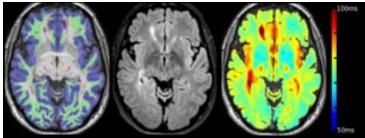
T1-weighted image showing segmentation of cortical gray matter (blue), juxtacortical white matter (green) and major white matter tracts (forceps minor, corticospinal tract, anterior thalamic radiation, inferior longitudinal fasciculus, red); T2-FLAIR showing white matter lesions; T1rho map.
